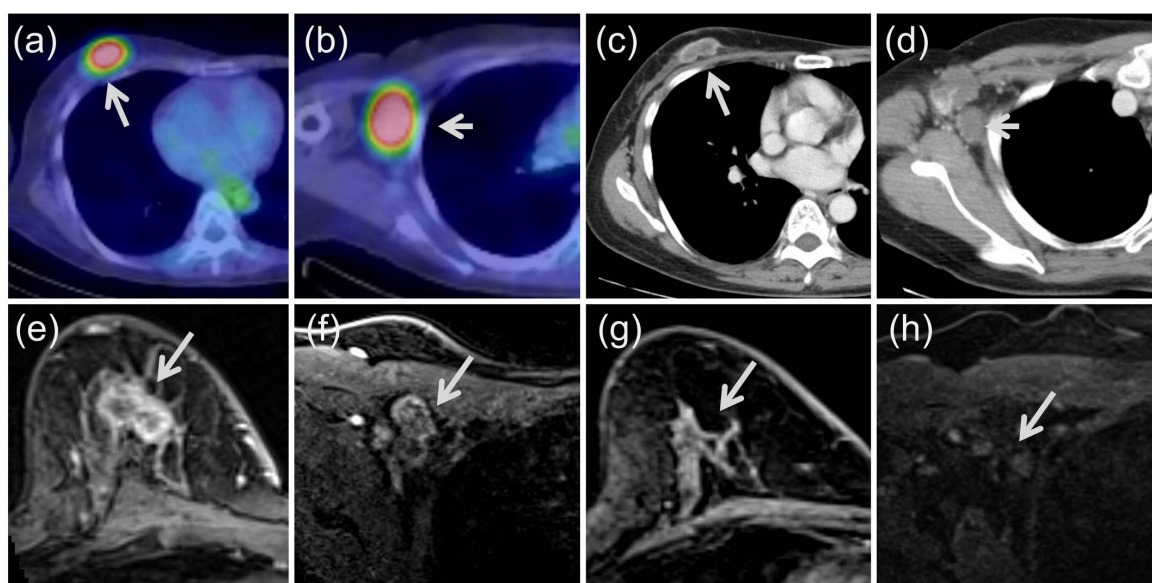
F18 fluorodeoxyglucose (FDG) positron emission tomography (PET) /computed tomography (CT), contrast-enhanced CT, and post-gadolinium T1-weighted magnetic resonance imaging (MRI). Hypermetabolic breast tumor (arrow) (a) and axillary lymph nodes (arrow) (b) were detected by FDG-PET/CT. Contrast-enhanced CT showed strong rim enhancement of the right breast cancer (arrow) (c), but minimal enhancement of the axillary lymph nodes (arrow) (d). Contrast-enhanced MRI showed an irregularly shaped breast cancer with heterogeneous rim enhancement (arrow) (e). Chest wall involvement was suspected due to adjacent tissue changes between the tumor and the chest wall. Axillary lymph nodes showed heterogeneous enhancement (arrow) (f). Contrast-enhanced MRI one year after high-dose adaptive radiotherapy showed no residual breast cancer (g) or axillary lymph node involvement (h)
